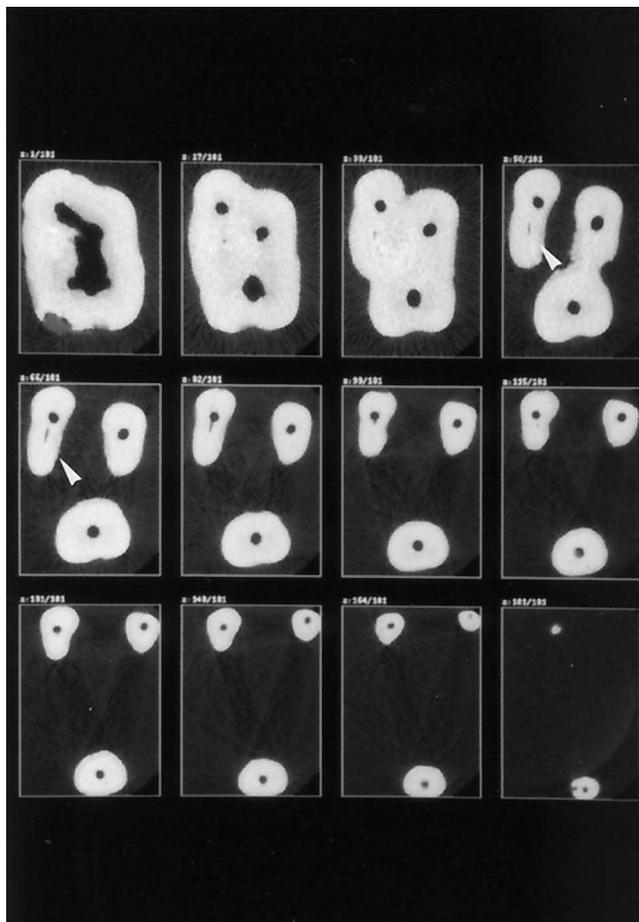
μ CT slices, extending from the pulp chamber to the root apices of an extracted maxillary first molar whose p, db, and mb canals were shaped with K-Files, Lightspeed, and ProFile .04 instruments, respectively. Note the unprepared mb 2 canal identified by arrowheads.
